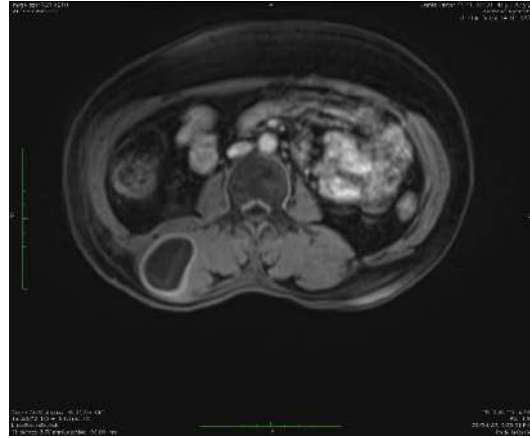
CT scan showing hydatid cyst of retroperitoneum.
